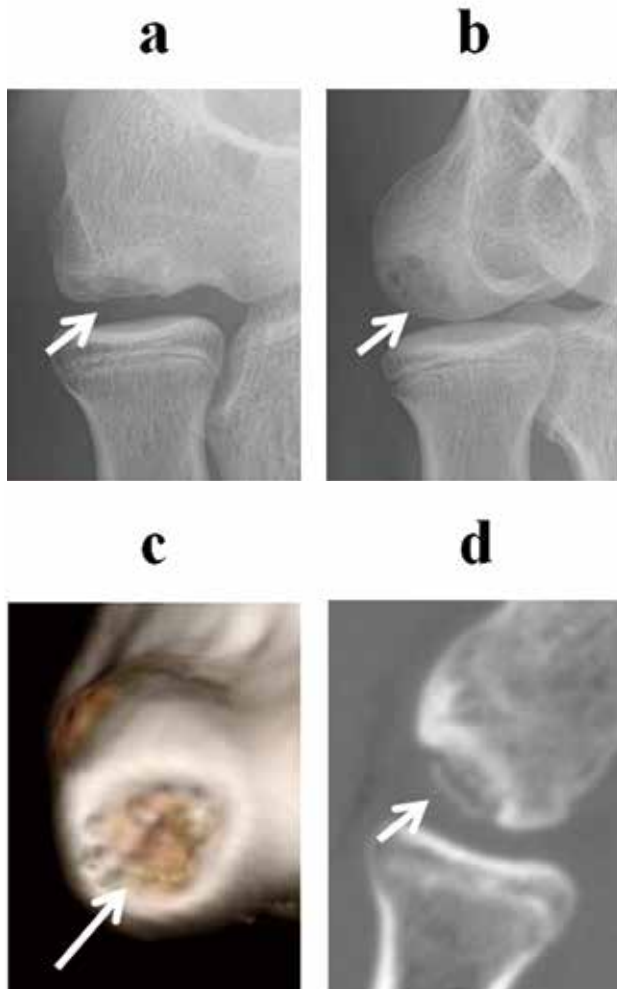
Computed tomography scans (c, d) can identify and localize a lesion and define its extent more accurately than radiographs (a, b).
